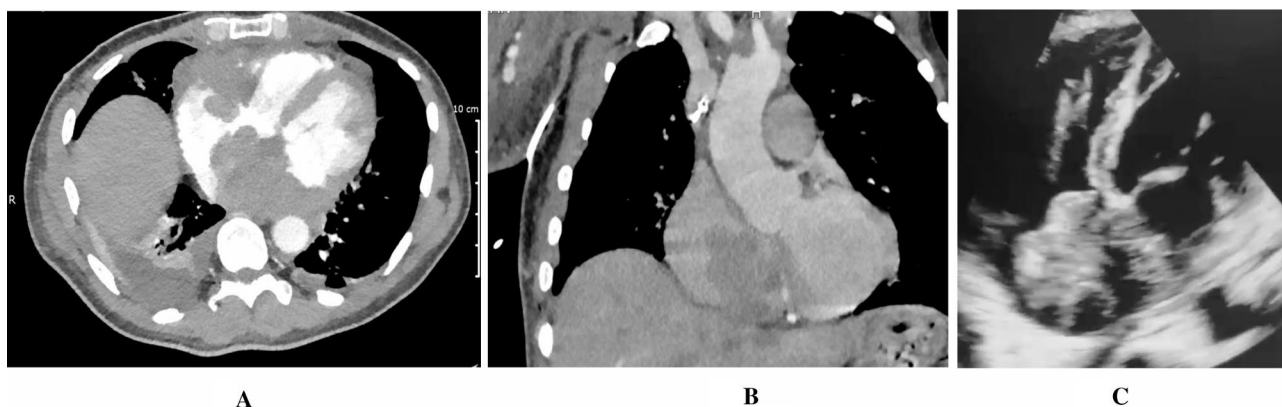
1/A et B Thoracic CT demonstrating a voluminous intra cardiac mass 1C/ Transthoracic echocardiography view depicting the intra right atrium tumour with tricuspid and septal involvement
